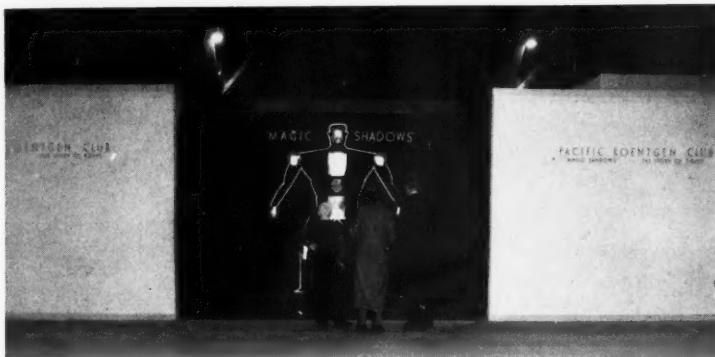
The Pacific Roentgen Club Exhibit at the California World's Fair. Portion of the front of the exhibit booth. (Note: This and the following photographs were made at "closing time" at which hour the public has largely vacated the pavilions.)
